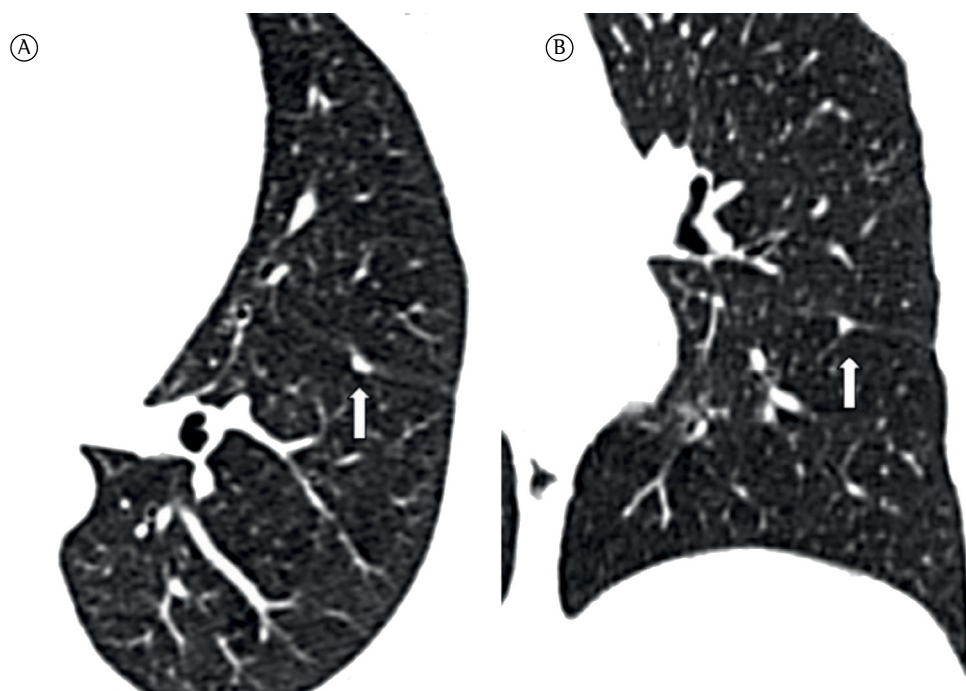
In A, an axial CT image of the chest (lung window) of a 53-year-old man. A triangular intrapulmonary lymph node (3 × 4 mm) is attached to the pleural fissure. In B, a coronal CT image (lung window) showing the triangular shape and septal contact (arrow) of the intrapulmonary lymph node.
